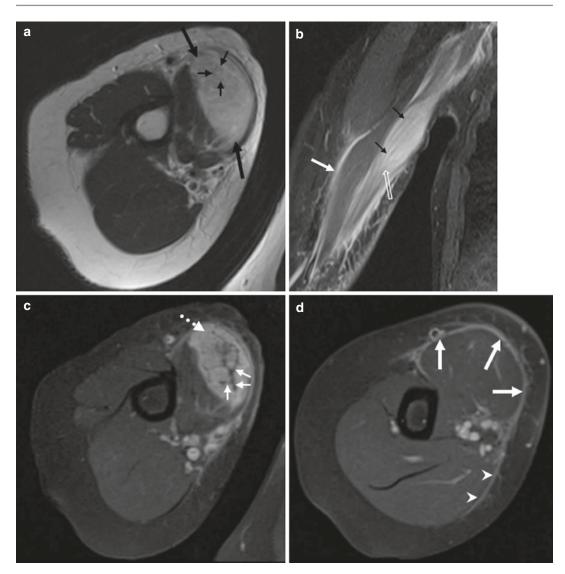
Proliferative myositis in a 52-year-old female aerobics instructor with 3-week history of a painful swelling in the anteromedial aspect of the upper arm. (a) Axial T2-weighted MRI view, (b) coronal STIR image, and (c, d) axial contrast-enhanced T1-weighted MR images. (a, b) The mass appears inhomogeneously hyperintense in T2-weighted image (*large black arrows*). The hypointensities within the lesion have geometrical contours on axial images – consistent with "checkerboard-like pattern" – and are clearly continued with muscle fascicles at the upper and lower pole of the tumor in coronal image (*small black arrows*). The inferior margin of the lesion cannot be
